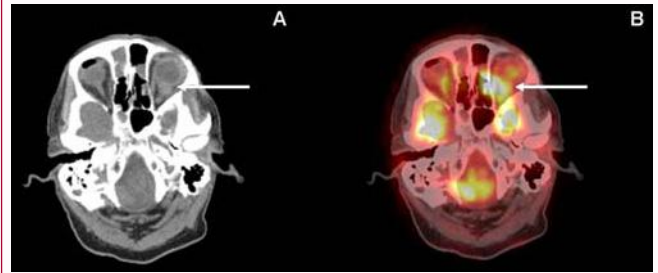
Transaxial follow up FDG PET/CT showing recurrence of the left orbital mass that appears hypermetabolic (arrow). CT image (A), PET/CT fusion image (B).
